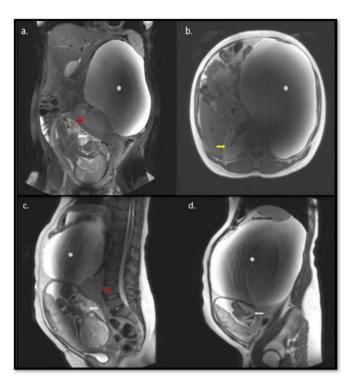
Magnetic resonance imaging of the retroperitoneal lymphangioma. T2 sequence: large retroperitoneal unilocular cystic mass with hyperintense content. a. Coronal section; b. Axial section; c. Mid-sagittal section; d. Left parasagittal section. *Retroperitoneal lymphangioma. Red arrow: left kidney with anterior, medial and inferior displacement. Yellow arrow: right kidney. (For interpretation of the references to color in this figure legend, the reader is referred to the web version of this article.)
